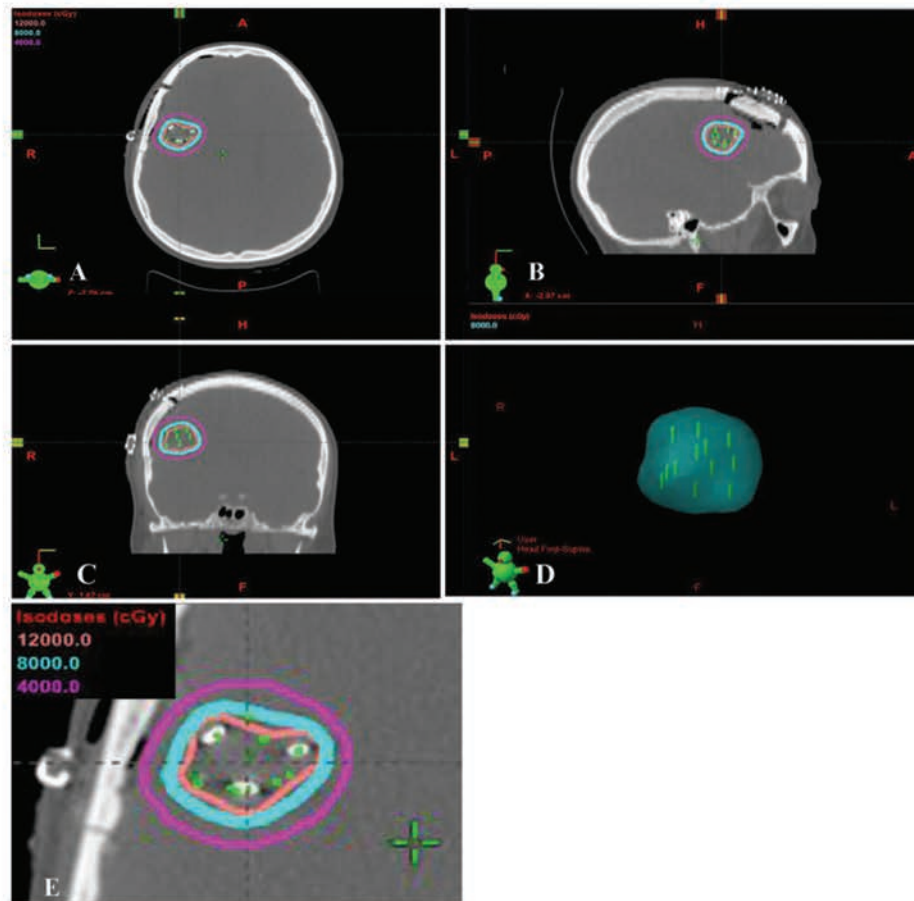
Computed tomography scans of ^{131}Cs brachytherapy seeds in the postoperative resection cavity. A: Axial plane. B: Sagittal plane. C: Coronal plane. D: Three-dimensional radiation cloud from the 80-Gy isodose line. E: Enlarged axial view of isodose lines.
